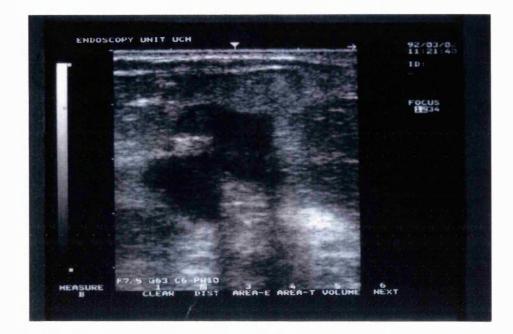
a) 14G needle inserted into the tumour under ultrasound control using the 7.5 MHz transducer and b) patient undergoing ILP.
